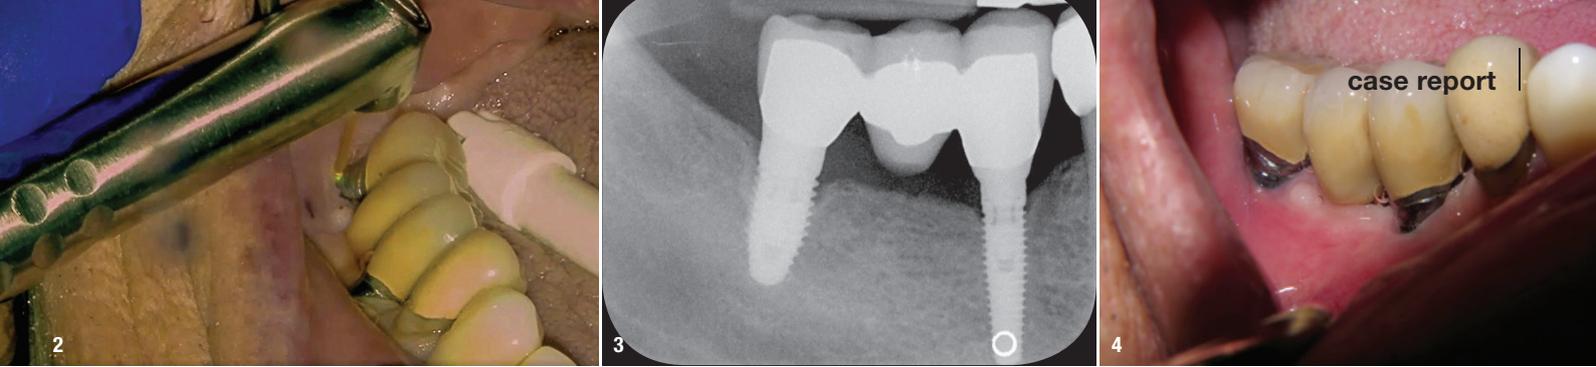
Degranulation using the Er:YAG laser. Fig. 3: Radiograph taken at the nine-month follow-up, showing bone healing. Fig. 4: Clinical situation at the nine-month follow-up.
